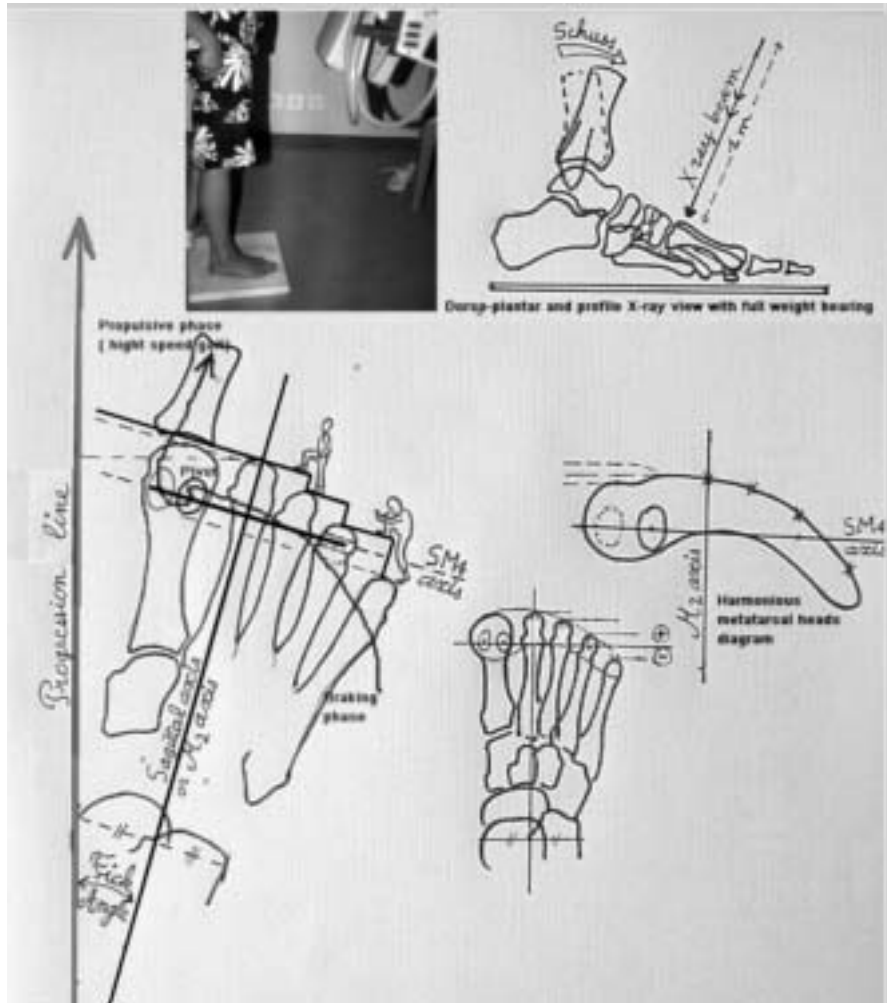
30a5a. Metatarsalgia – Main causes: 4) Metatarsal excess of length a1) In dorso-plantar X-ray in standing position.
